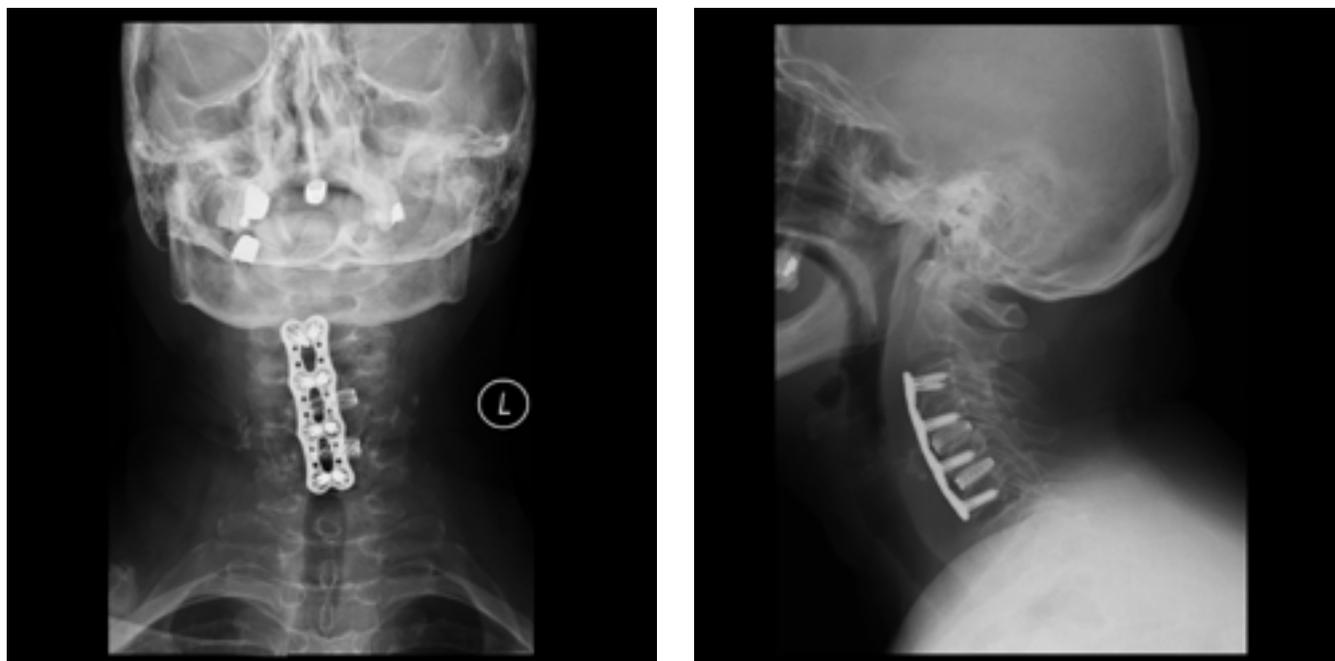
X-radiograph of cervical segment post-surgery: sitting position, AP position (A), lateral position (B). Date of examination: December 27, 2018.
